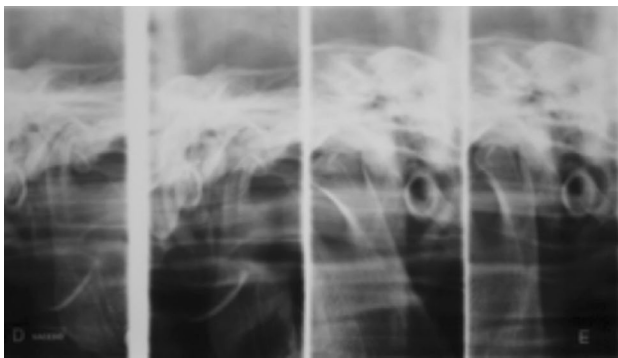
Temporomandibular joint radiograph of the case. Note that the left mandible head and condyle is larger than right mandible head and condyle
